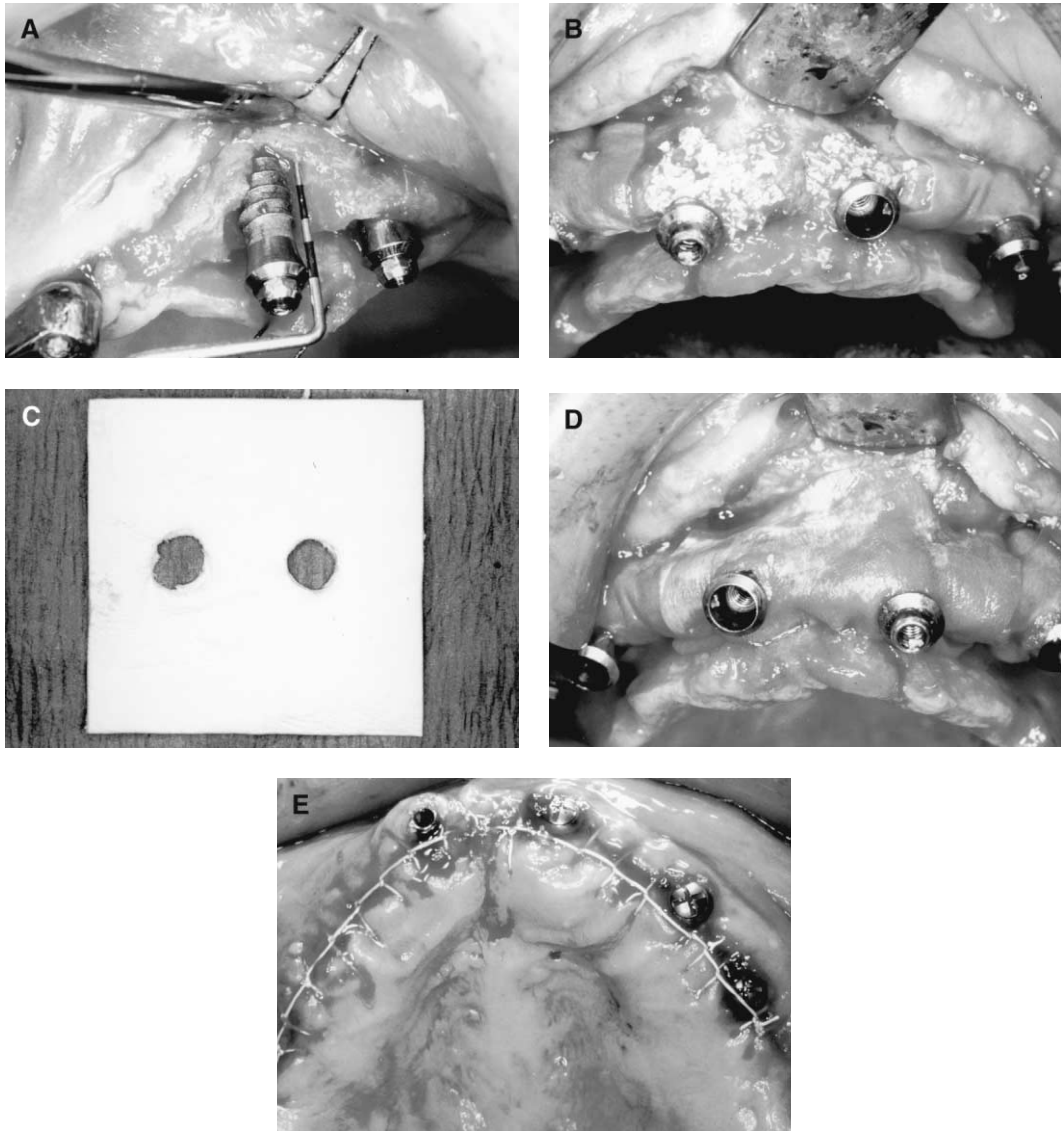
Guided bone regeneration around a failing implant. (A) Large bony defect of a rough surface implant with increased probing depths and radiographic evidence of bone loss. (B) Bony defect covered with graft material after surface débridement and decontamination with tetracycline HCl paste. (C) Resorbable collagen membrane prepared to cover the graft material and necks of implants. (D) Collagen membrane in place. (E) Water-tight closure around implants and surgical site (some authors advocate burying single-stage implant systems after this procedure). (Courtesy of Dr. Tinou Roncone.)
